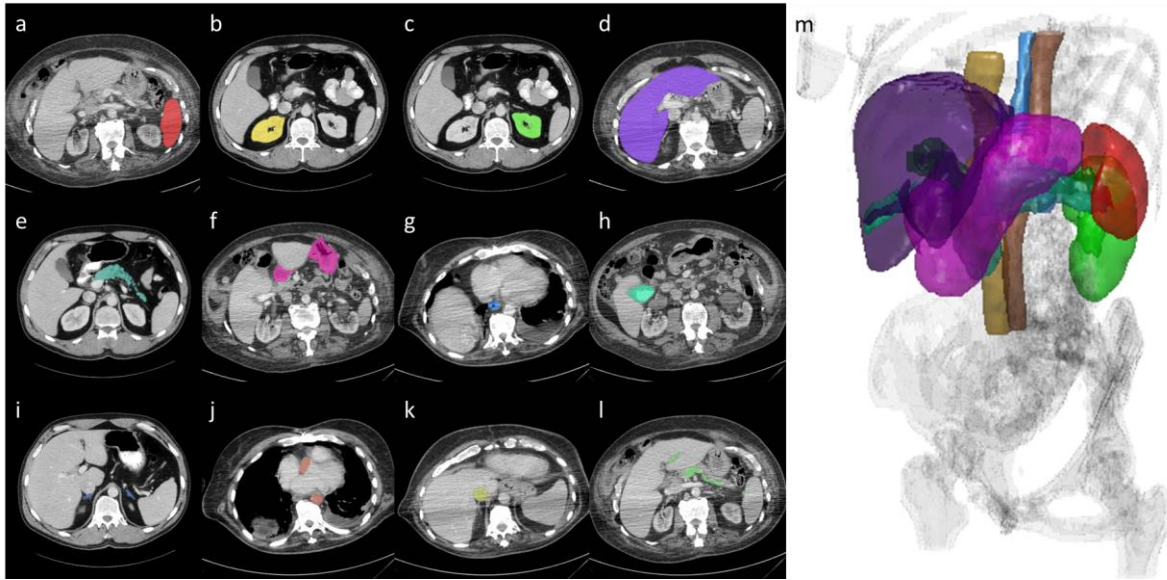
Abdominal Viscera in CT: (a) spleen; (b) right kidney; (c) left kidney; (d) liver; (e) pancreas; (f) stomach; (g) esophagus; (h) gallbladder; (i) adrenal glands; (j) aorta; (k) inferior vena cava; (l) portal vein and splenic vein; (m) surface rendering of abdominal viscera.
